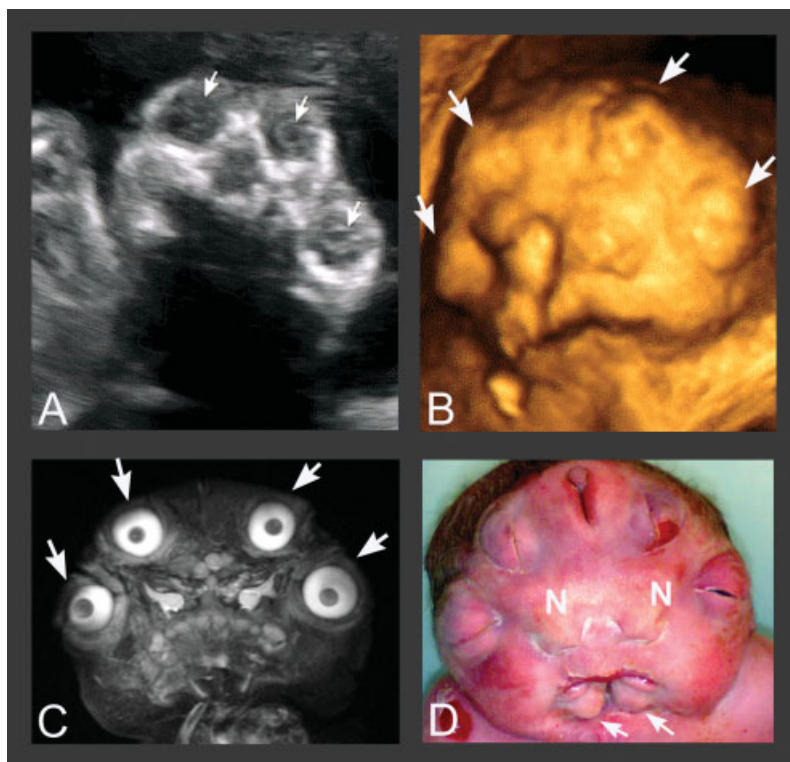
Partial facial duplication in diprosopus as demonstrated at 22 weeks of gestation by two-dimensional (A) and three-dimensional ultrasound (B), post-mortem by magnetic resonance imaging (MRI) (C), and at birth (D). Note the four orbits (arrows), the two noses (N), and the two fused buccal orifices (arrows in D)
